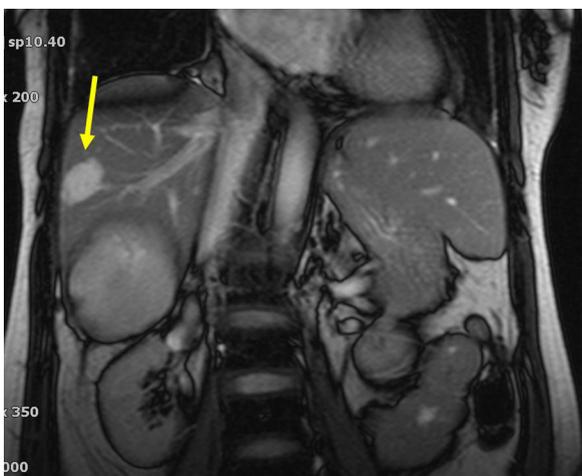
MRI reveals a possible liver haemangioma close to the resolving haematoma.
